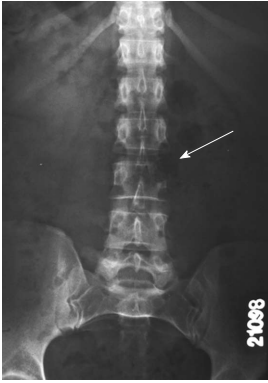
The (absent) pedicle sign known as the winking owl sign (arrow). A reliable sign of osteolytic spinal metastases on antero-posterior radiographs is loss of the normal pedicle contour.
